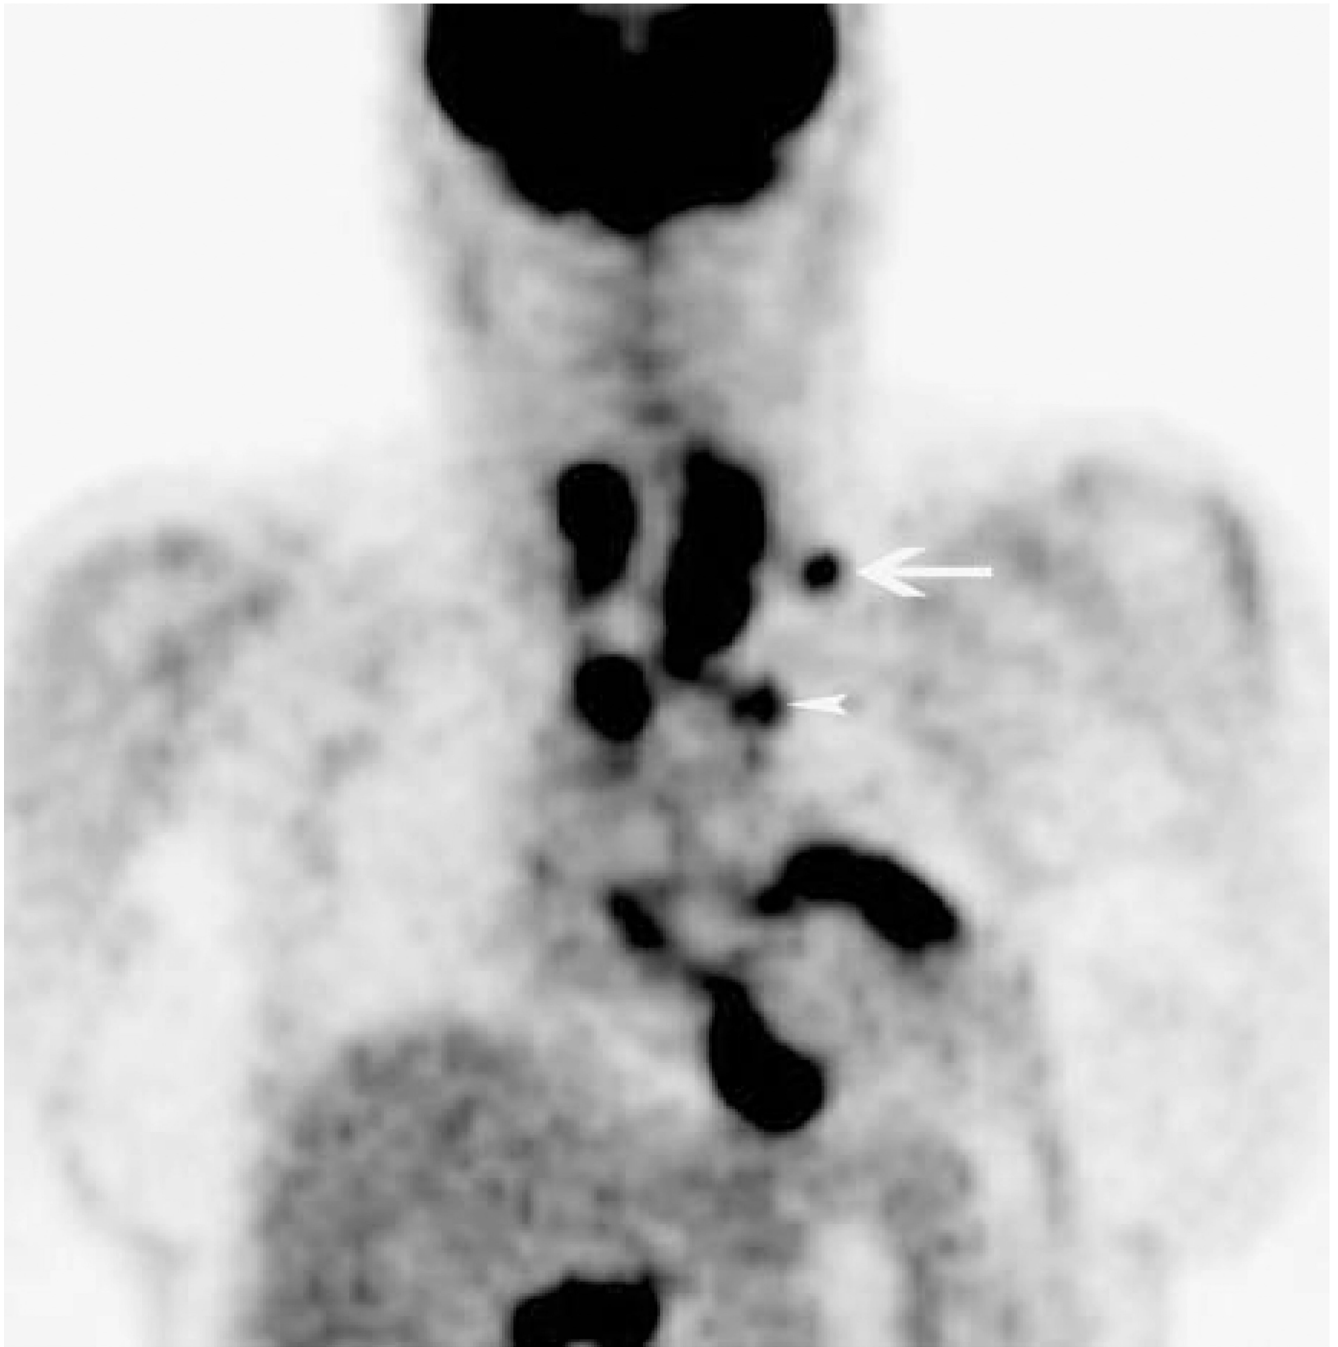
Coronal image from the ^{18}F FDG PET study demonstrates ^{18}F FDG avid left supra clavicular node and mediastinal nodes (*white arrows*) and myocardium.
